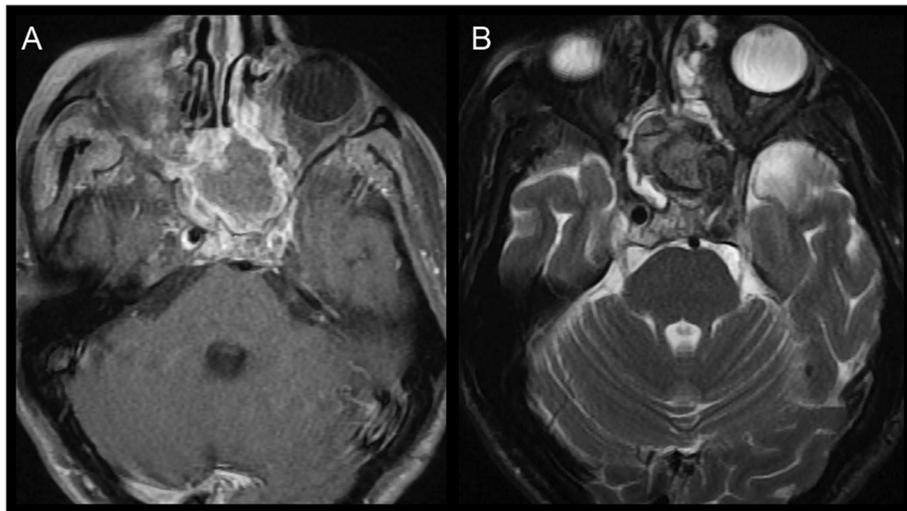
MR images after coil embolization of a cavernous pseudoaneurysm. These images show that there is no flow in the pseudoaneurysm and in the left ICA. A) T1 axial sequence with contrast, B) T2 axial TSE sequence.
